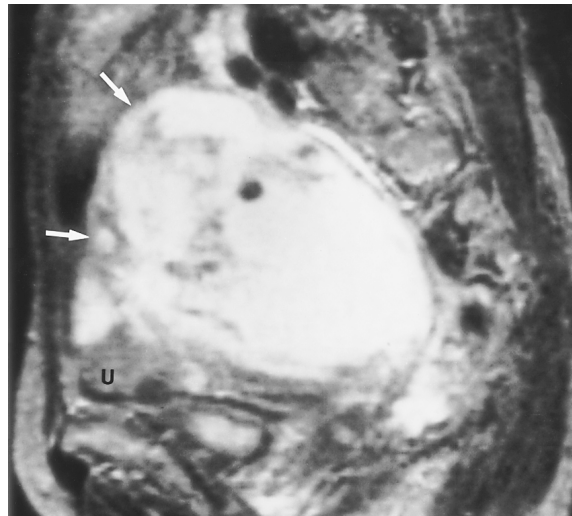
Subserosal leiomyoma with extensive cystic degeneration in a 61-year-old woman. (a, b) Sagittal spin-echo T1-weighted (600/25) (a) and T2-weighted (2,000/70) (b) MR images show a mass posterior to the uterus (*U*) (arrows). The signal intensity of the mass corresponds to fluid mixed with thin, interlacing tissue of intermediate signal intensity on both images. (c) Photograph of the cut surface of the resected lesion shows an almost entirely cystic mass with scanty solid tissue. (Reprinted, with permission, from reference 4.)
